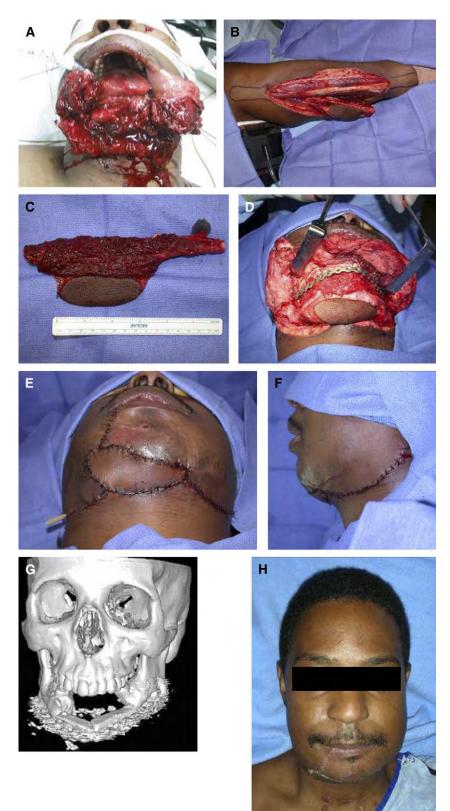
(A) Patient s/p gun shot wound to face. Note the extensive soft tissue and bony defect. (B) Harvesting of osseomyocutaneous fibula flap to reconstruct defect using the principle of replacing "like with like" tissue. (C) Harvested osseomyocutaneous fibula free flap before contouring. (D) Inset of flap into the defect site after two closing osteotomies. Note the position of the skin and muscle flap to reconstruct the missing tissues in the submental region. (E, F) Closure of skin flaps. Note the recapitulation of the normal lower facial contour and projection. (G) Three-dimensional CT scan of the reconstructed mandible shows the inset of the fibula with the closing midline osteotomy. Note excellent bone width and height for the eventual placement of dental implants. (H) Facial appearance of patient at 1 week after reconstruction.
